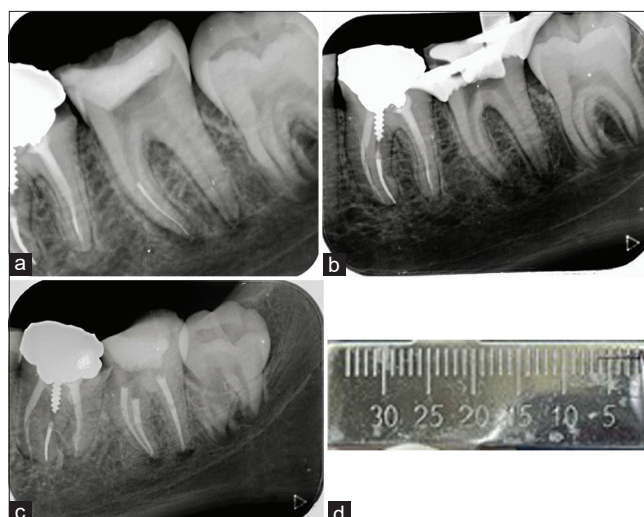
Case 2 with a separated instrument in tooth #18. a) Radiographic examination showing a separated instrument in the MB canal. b) The instrument was retrieved from the canal and confirmed with a radiograph. c) Root canal treatment completed. d) The length of the separated instrument.
